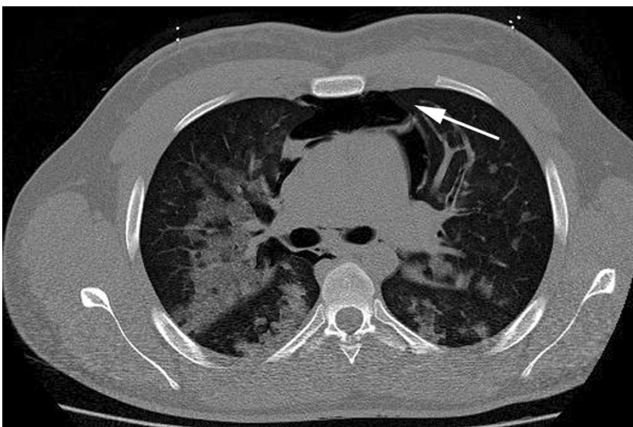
Chest CT-scan shows bilateral diffuse pulmonary infiltrates and the presence of coexisting pneumomediastinum (white arrow). CT, computed tomography.
